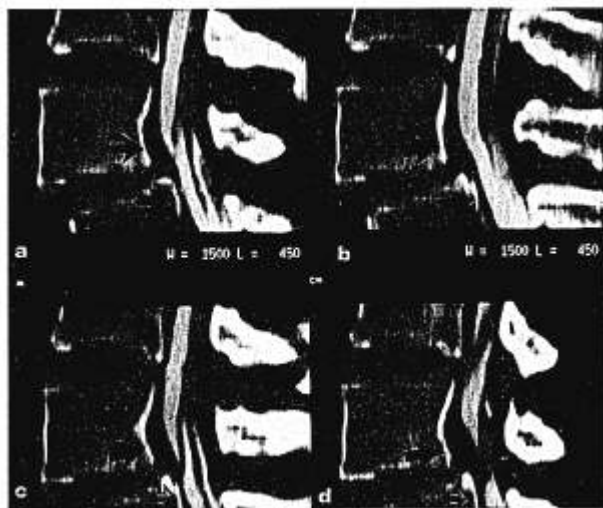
Sagittal and parasagittal two-dimensional myelo-computed tomography (CT) study demonstrating L4–L5 degenerative spondylolisthesis (case 1). a: Parasagittal two-dimensional (2D) myelo-CT. This parasagittal myelo-CT study showed a less than grade I olisthy (black arrows) and minimal thecal sac intrusion at L4–L5 in this 47-year-old woman. b: Midline 2D myelo-CT. The midline myelo-CT showed only mild L4–L5 olisthy (white arrows), which did not significantly compress the thecal sac. c: Parasagittal 2D myelo-CT. The contralateral parasagittal myelo-CT study also demonstrated the lack of significant L4–L5 thecal sac compression (black arrows). d: More lateral parasagittal 2D myelo-CT. The more lateral parasagittal myelo-CT revealed slightly greater thecal sac intrusion in a narrowed L4–L5 (black arrows) lateral recess. Because these and the transaxial studies failed to confirm significant stenosis at the level of olisthy, no surgery was performed.
